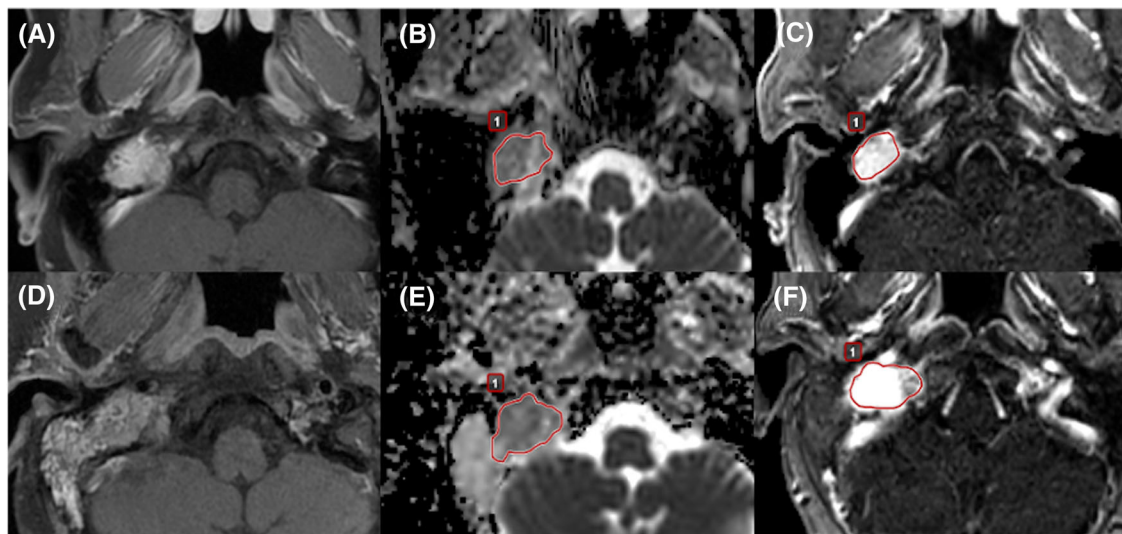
A 69-year-old female with paraganglioma in the right jugular foramen. (A) Post-contrast T1-weighted image, (B) apparent diffusion coefficient (ADC) map, and (C) permeability map demonstrate a pretreatment paraganglioma in the right jugular foramen. (D) Post-contrast T1-weighted image, (E) ADC map, and (F) permeability map demonstrate a post-treatment paraganglioma. A freehand region of interest (ROI) is placed on (B) and (E) ADC maps, and pre- and post-treatment ADC values are calculated. Another freehand ROI is placed on (C) and (F) permeability maps, and quantitative parameters are calculated. In this case, the tumor grows after external beam radiation therapy. In addition, the tumor invades the right mastoid air cells and results in opacification
